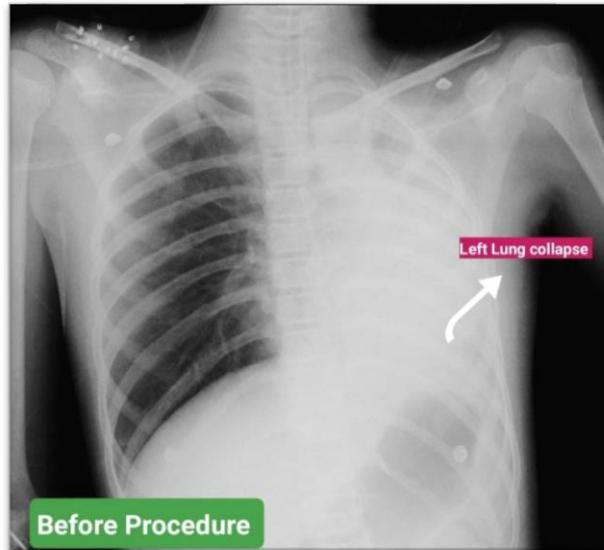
Pre-op x-ray showing left lung collapse of 12 yr old child
